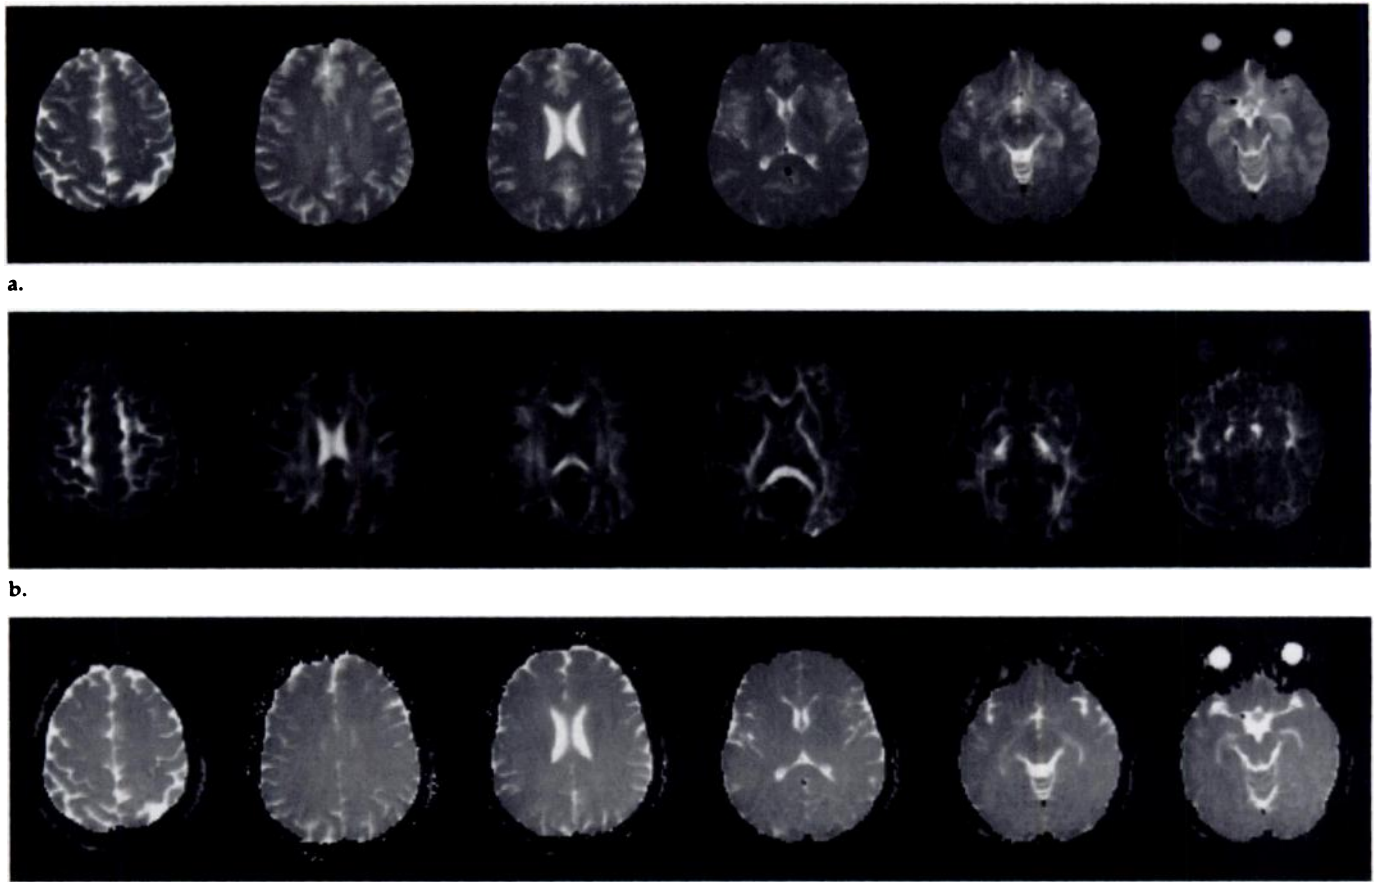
Axial maps of (a) the T2-weighted amplitude, (b) the (Lattice) anisotropy index, and (c) Trace(D) in a 33-year-old healthy woman. Anisotropy index images clearly show anisotropic white matter regions as hyperintense and isotropic CSF and gray matter as hypointense. However, the degree of anisotropy varies widely among white matter regions, with higher intensity observed in regions where the fiber pattern is more coherent and lower intensity where it is more incoherent. Note that iron-rich regions, such as the pallidum, the substantia nigra, and the red nucleus, which all appear hypointense in a, appear dark in b, which permits identification of the neighboring pyramidal tract. c clearly shows CSF regions as hyperintense and tissue (gray and white matter regions) as hypointense.
